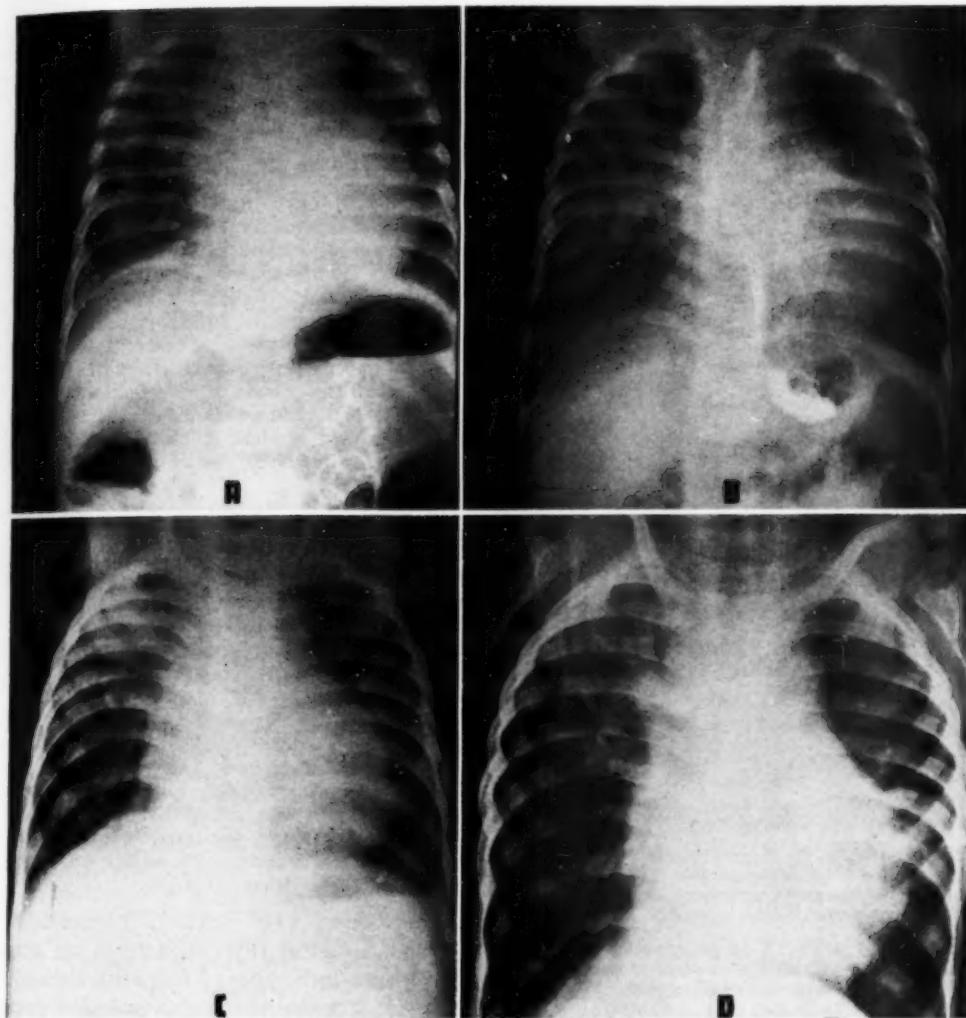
Case IV. A. Roentgenogram at three months of age, showing infiltration of the right upper lobe, emphysema of the right lower and left lung fields, and cardiac enlargement. B. At six months of age. The right upper lobe infiltration has resolved, and there is now middle lobe infiltration. C. At seven months. The middle lobe has cleared, and infiltration is again evident in the right upper lobe. D. At one and a half years of age. The right upper lobe process continues and there is now marked emphysema. The heart is still enlarged.
